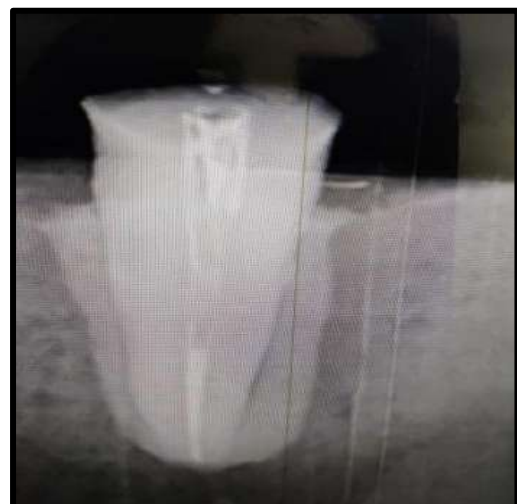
Armamentarium and radiographic evaluation of obturation , post space preparation and placement
